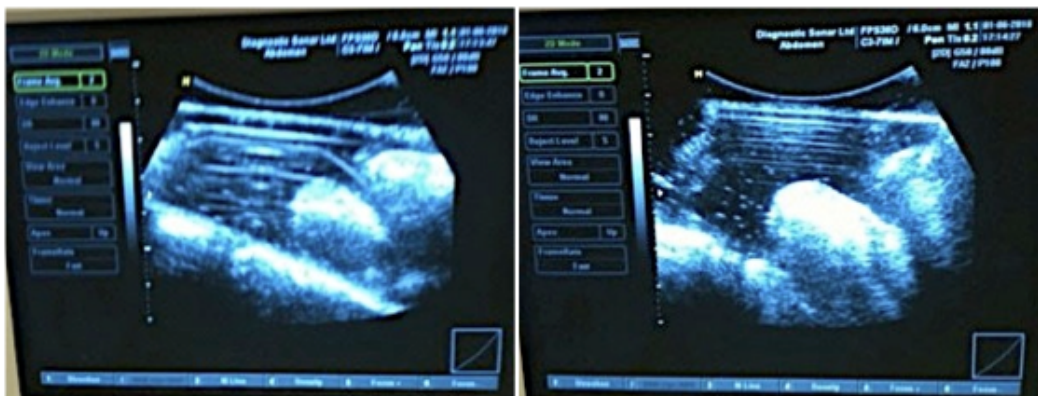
Ultrasound imaging with support plates above the transducer: P1-E (left); PK-E (right).
